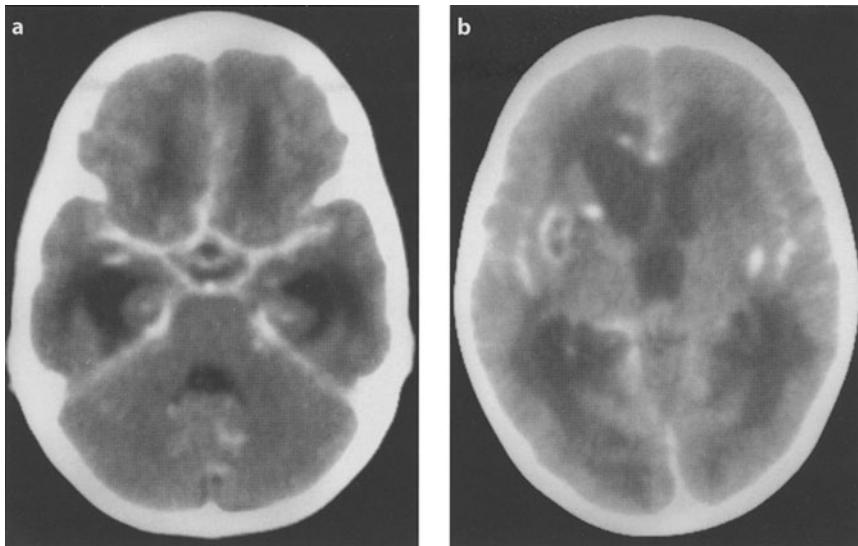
Hydrocephalus secondary to tuberculosis. Axial CT scan after contrast injection. Ventricular dilatation is seen as well as periventricular hypodensity. Cistern and basal ganglia enhancement is present
